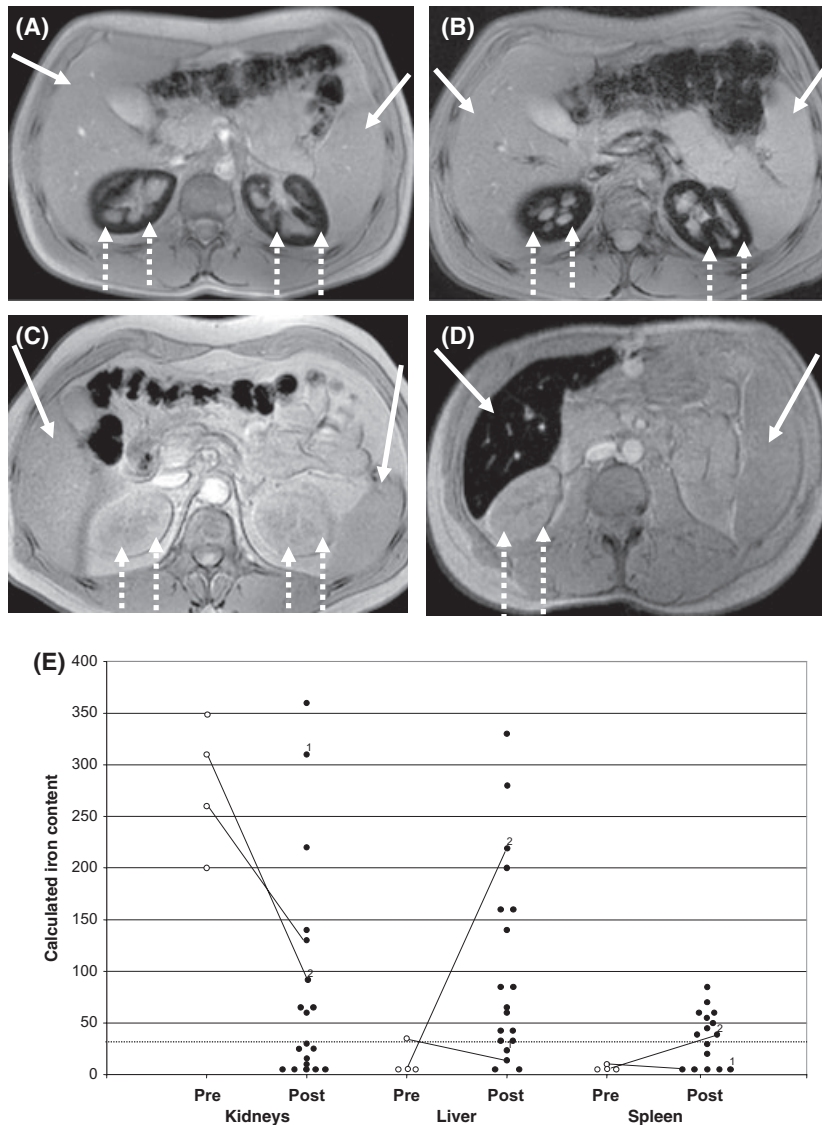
Iron compartmentalization by magnetic resonance imaging (MRI) in PNH patients. After informed consent, T2* MRI was performed by a 1.5 tesla whole body scanner (Gyrosan, Philips, Andover, MA, USA), using four gradient-echo sequences and one spin-echo sequence. Due to paramagnetic properties of iron, iron overload results in decreased T2* relaxation time at MRI. This gives a typical image of the involved organ, with decreased (black) signal intensity (SI) corresponding to iron overload, while organs with normal iron content appear white. SI was measured on images obtained with each sequence by means of three regions of interest placed in the liver and at the level of the para-spinal muscle. SI ratios were obtained in comparison to muscle, and finally converted into organ calculated iron content (CIC) according to the validated method described by Gandon *et al* (1994). CIC of the liver was expressed as $\mu\text{mol/g}$ (Gandon *et al*, 1994; Deugnier & Turlin, 2007), whereas for the kidneys and the spleen CICs were reported as arbitrary units because the formal validation on tissue biopsies has never been performed for ethical and medical reasons. (A) Example of an untreated PNH patient (UPN NA111): MR image demonstrates a high renal CIC (dashed white arrows) and normal hepatosplenic CIC (white arrows). (B) Example of a PNH patient on eculizumab experiencing breakthrough (UPN NA102): MR image demonstrates a high renal CIC (dashed white arrows) and normal hepatosplenic CIC (white arrows), similarly to untreated patients. (C) Example of a PNH patient on eculizumab with complete blockade of intravascular haemolysis (UPN NA006): MR image demonstrates normal renal CIC in the kidneys (dashed white arrows), liver and spleen (white arrows). (D) Example of a PNH patient on eculizumab with iron overload (UPN RM003): MR image demonstrates a normal renal CIC (dashed white arrows) and high hepatic CIC (white arrow). (E) Calculated iron content in kidneys, liver and spleen as determined by MRI: organ specific CIC were obtained using the same formula (Gandon *et al*, 1994), but are expressed as either $\mu\text{mol/g}$ of tissue (liver) or arbitrary units (kidneys and spleen). Each dot represents a single case, with the exception of those tagged as 1 and 2, which refer to the same patient studied at 1 and 6 months from treatment initiation; pre- and post-treatment data (when available) are joined by a continuous line. The dotted line represents the normal range for liver CIC.
